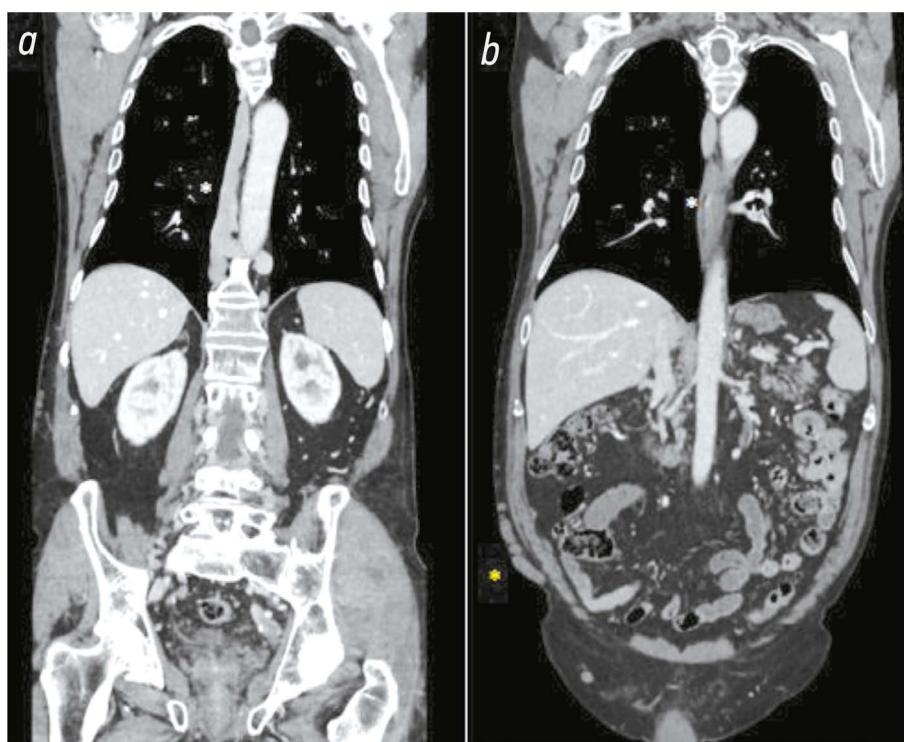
Computed tomography images of the coronal section and portal phase of the chest and abdomen: *a*) The white asterisk indicates the confluence of the giant azygos, hemiazygos, and an aberrant vein. *b*) Same image at different sections. The yellow asterisk on the right side at the level of the anterior abdominal wall indicates marked collateral vein circles.
